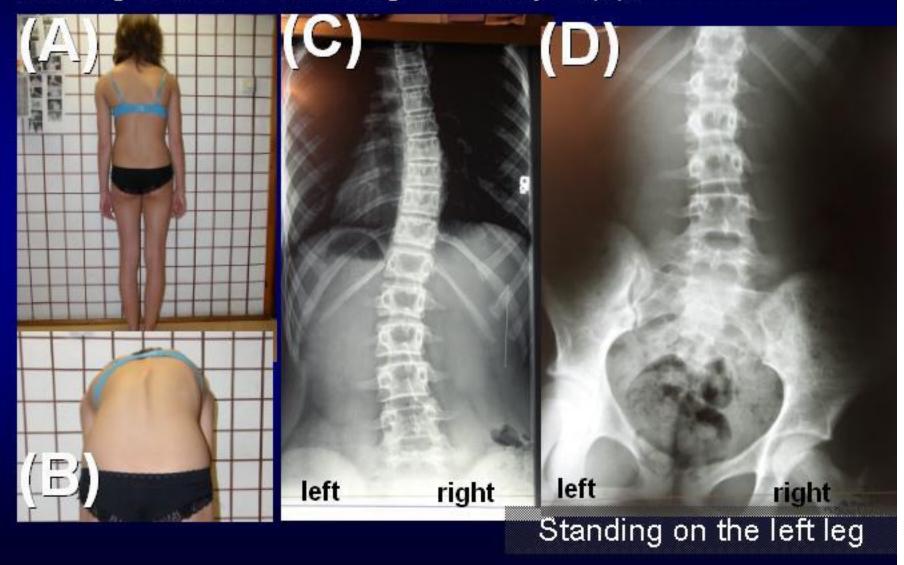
Patient 13 y. old. Scoliosis diagnosed in 2008 (A) (B) (C). Primary wrong therapy - in result bigger curves. After consultation – proper therapy, bending exercises, sport and standing 'at ease' on the left leg – see X-ray on (D).
